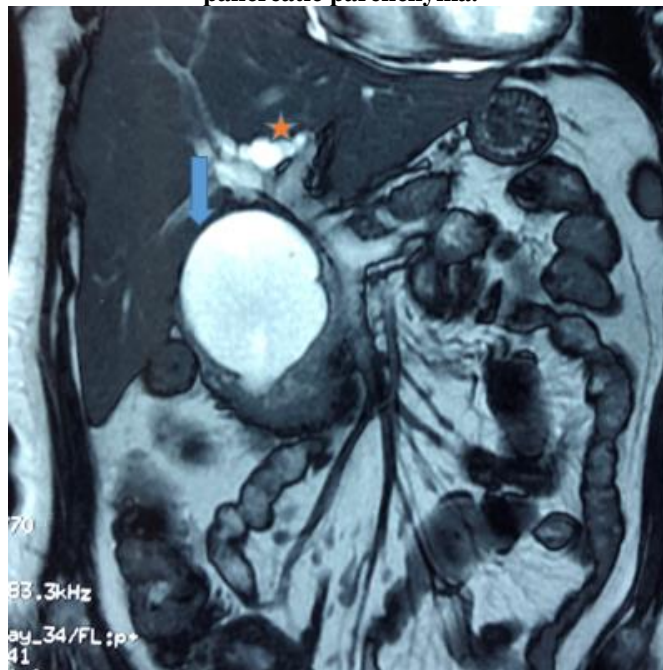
Abdominal MRI T2-weighted coronal slice showing a spindle-shaped cystic dilatation of the main bile duct () with thin wall and fluid content of the homogeneous signal and identical to the bile with slight dilatation upstream of the intrahepatic bile ducts (★).
